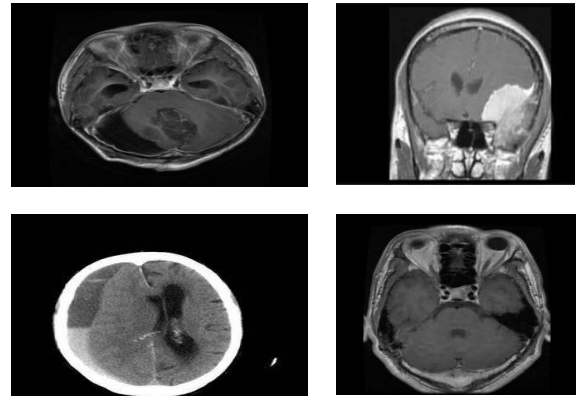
Brain MRI Scans for Brain Tumor Classification
